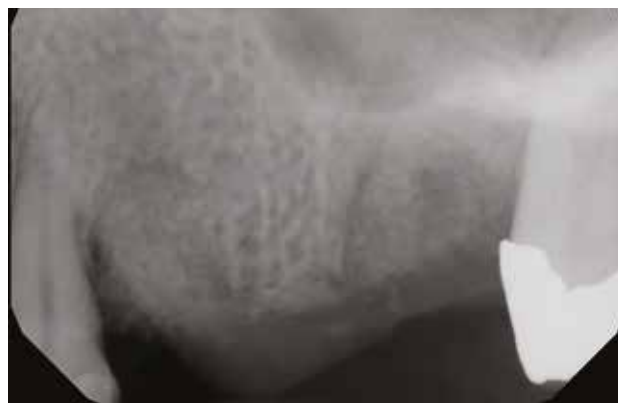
Radiograph following extraction of the bridge abutments, socket curettage and socket grafting demonstrating a granular appearance of the graft material.
